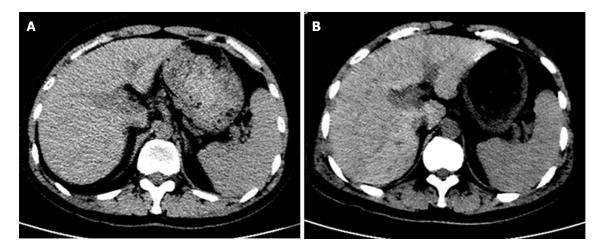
Abdominal computed tomography of the patient during hospitalization. A: On preoperative day 5, the morphology and density of the liver were normal; B: On postoperative day 9, the density of several parts of the liver was low.
